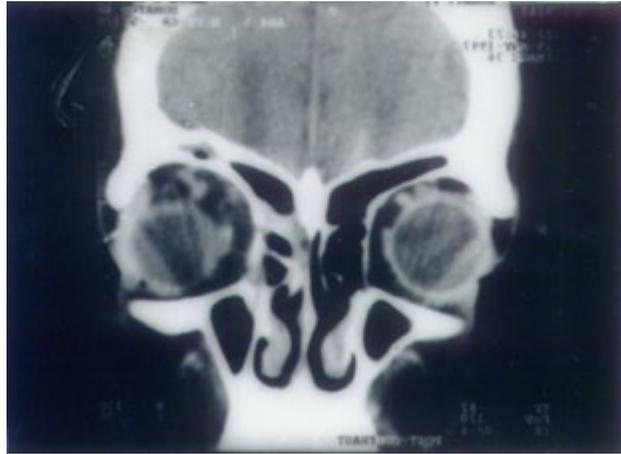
CT scan showing soft tissue in left ethmoid sinus with erosion of the medial orbital wall
